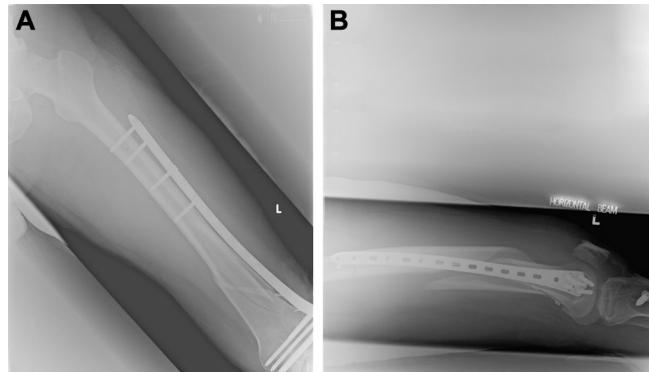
(A) Anteroposterior and (B) lateral radiographs of the left femur after open reduction and internal fixation with a less invasive stabilization system (LISS) plate.
